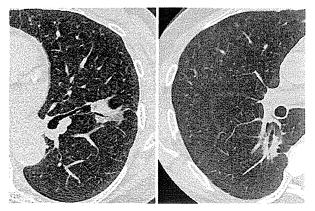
Typical images of pure-solid lung cancer with air bronchogram. An air-filled bronchus is surrounded by a lung tumour that only shows consolidation without ground-grass opacity on thin-section CT scan.
